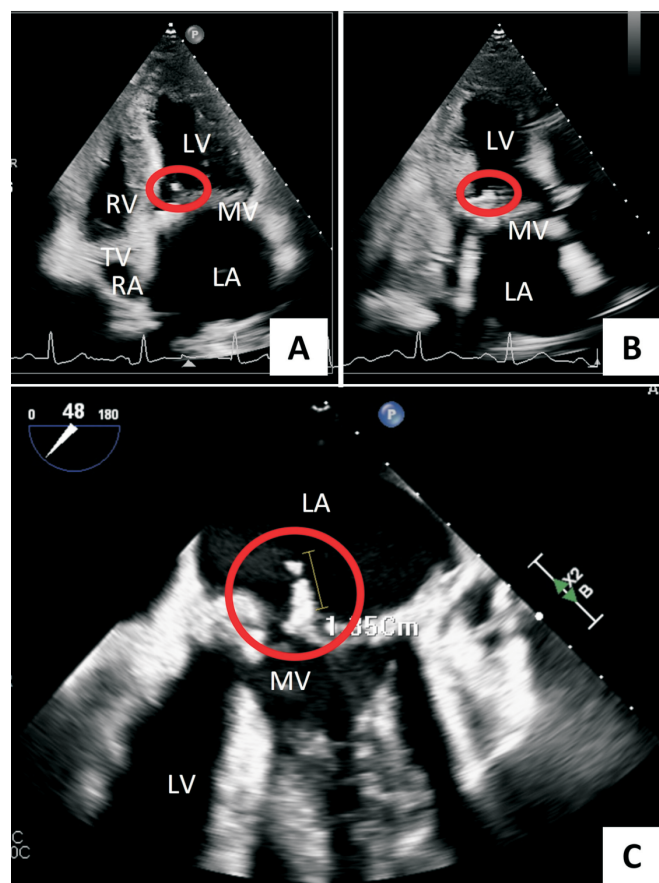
Echocardiogram of the case during hospitalization. Transthoracic echocardiography apical four chambers view (A) and two chambers view (B) showed vegetation on mitral annulus, marked by red circles. (C) Transesophageal echocardiography revealed fluttering vegetations on MV during diastolic phase, marked by red circles. Abbreviations on figure: LA, left atrium; LV, left ventricle; MV, mitral valve; RA, right atrium; RV, right ventricle; TV, tricuspid valve.
